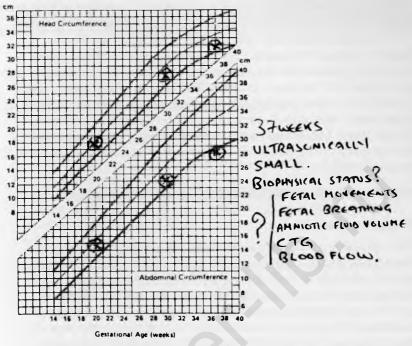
Ultrasound chart - small for dates.
